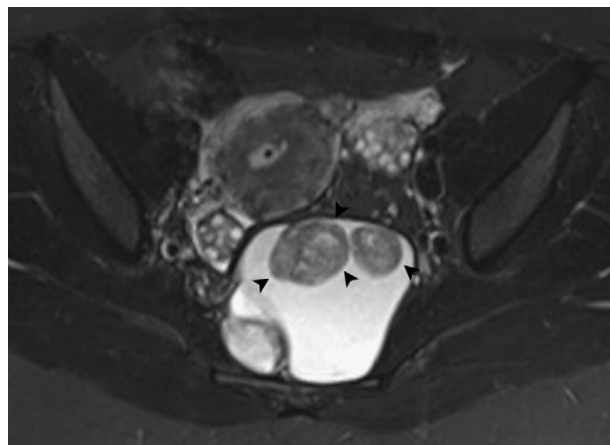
Epidermoid cyst in a 25-year-old woman with a history of lower abdominal pain. Fat suppressed T2-weighted MR images show a bilobulated cystic lesion with spheres of keratin debris inside the largest cyst (arrowheads).
